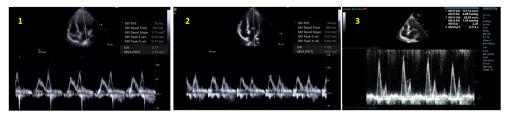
Figure nr. a.2.4. The three patterns of diastolic dysfunction: 1- type 1, E<A, E/A=0.71; 2-type 2, E>A, E/A=1.02; 1- type 3, E>>A, E/A>2; E/A=2.26 (PW Doppler)
